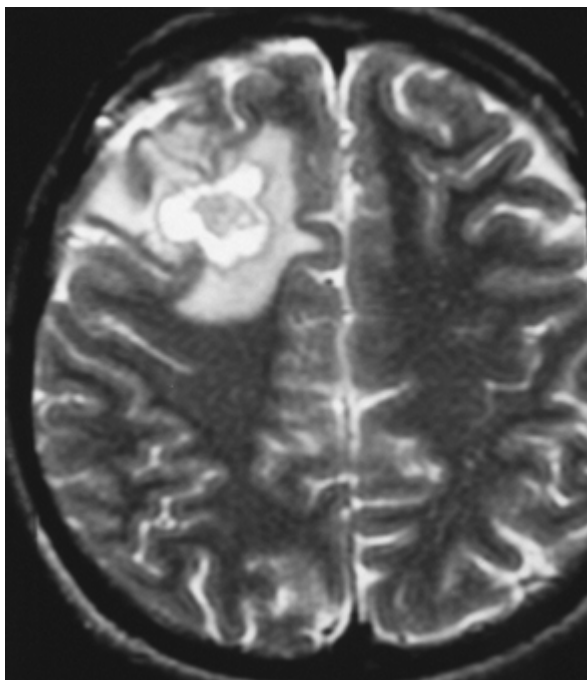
T2-weighted MRI of patient with intracranial tuberculoma showing characteristic “target” appearance of lesion.
